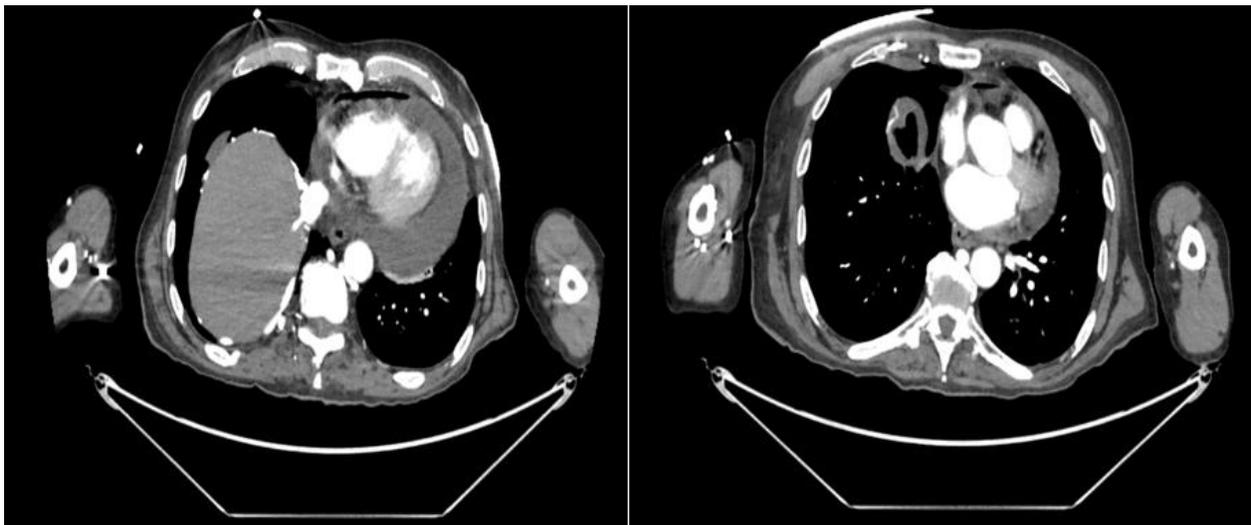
CTA showing large pericardial effusion and pneumopericardium.
